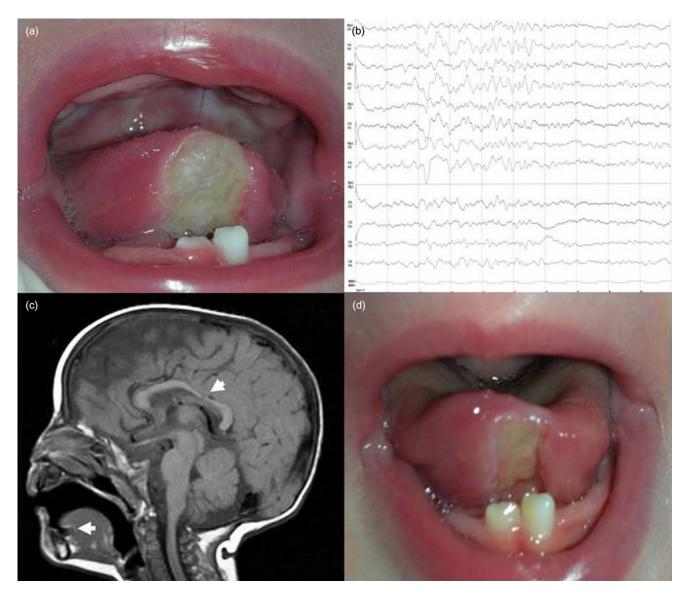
(a) Clinical features of the oral ulcer: it appears ovoid in shape, well circumscribed, with raised and indurated edges and with a yellowish fibrinous base. (b) Electroencephalogram examination: it shows a bihemispheric slow frequency rhythms. (c) Magnetic resonance imaging showing a thinning of the *corpus callosum* (upper arrow) and the tongue ulceration (lower arrow). (d) Clinical amelioration of the lingual lesion after the treatment.
